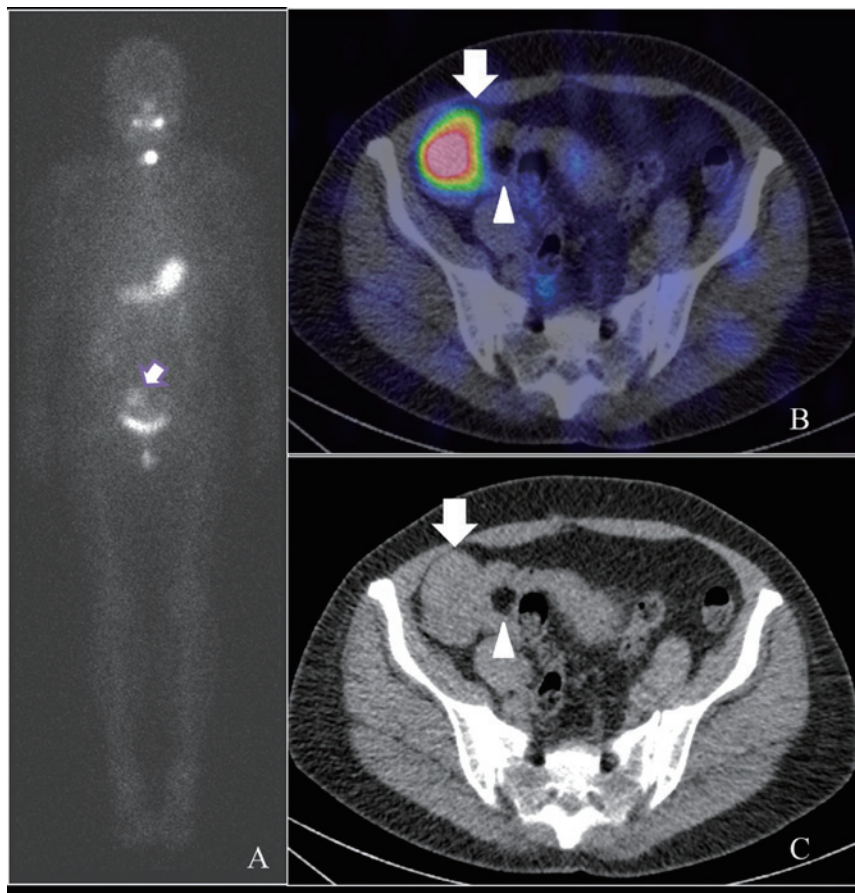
The radioiodine WBS (A) and SPECT/CT scans (B, C)
